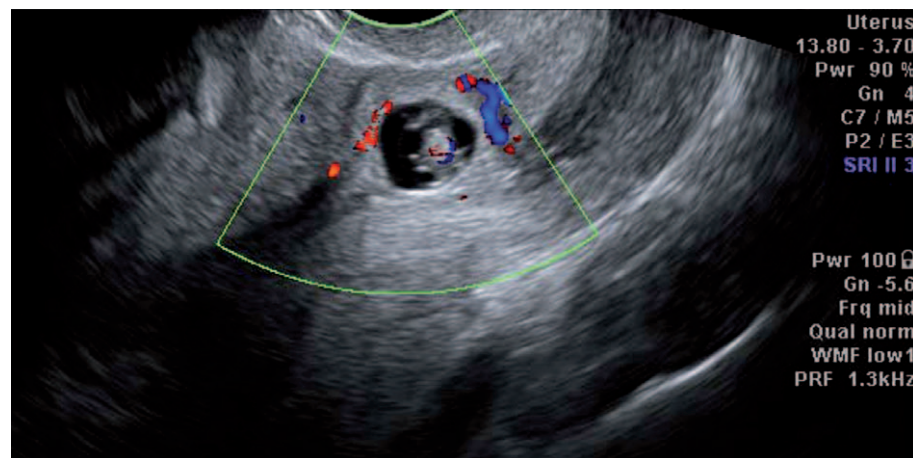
Transvaginal sonogram of the caesarean scar pregnancy, showing the empty uterine cavity and the empty cervical canal. The gestational sac is located in the thin lower anterior wall of the uterus behind a caesarean section scar and protrudes toward the urinary bladder. A rich vasculature surrounds the gestational sac.
